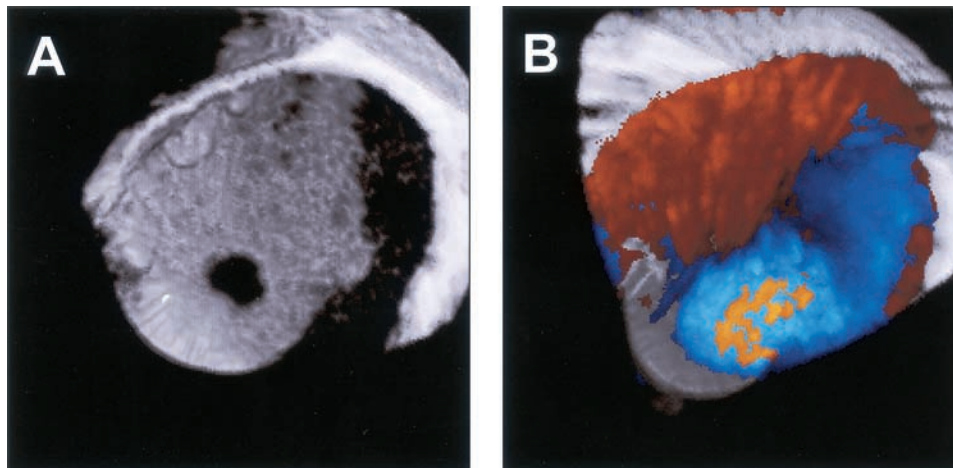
A, Three-dimensional echocardiogram demonstrating shape of entry. View is from false lumen. B, Tornado-like blood flow from true lumen to false lumen.
